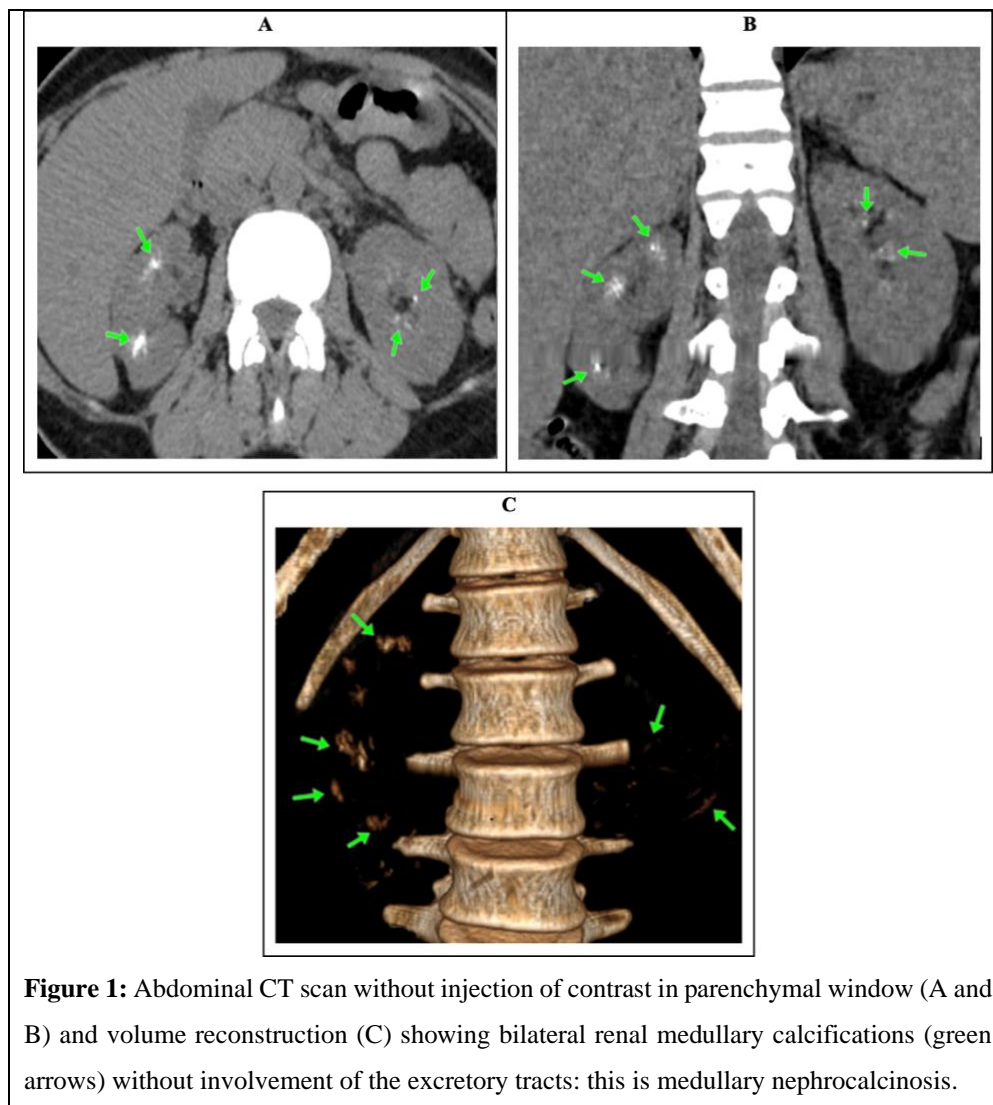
Abdominal CT scan without injection of contrast in parenchymal window (A and B) and volume reconstruction (C) showing bilateral renal medullary calcifications (green arrows) without involvement of the excretory tracts: this is medullary nephrocalcinosis.
